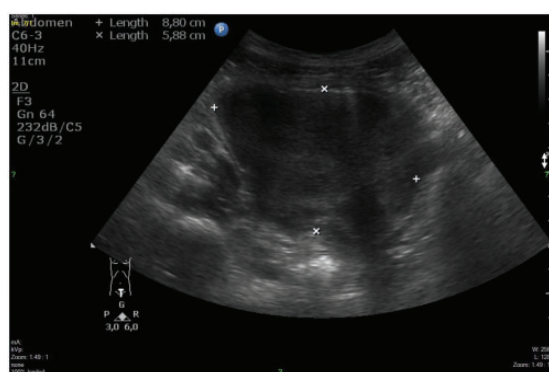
Transabdominal ultrasonography of right lower quadrant revealed an inhomogeneous hypoechoic mass above the urinary bladder.
